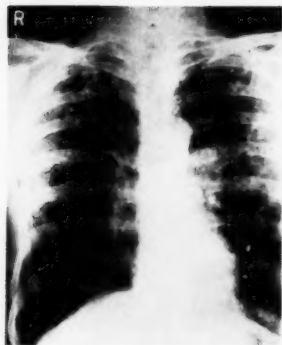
Radiograph of boiler scaler's lungs showing nodulation in outer and upper lateral zones and reticulation over rest of lung fields.
